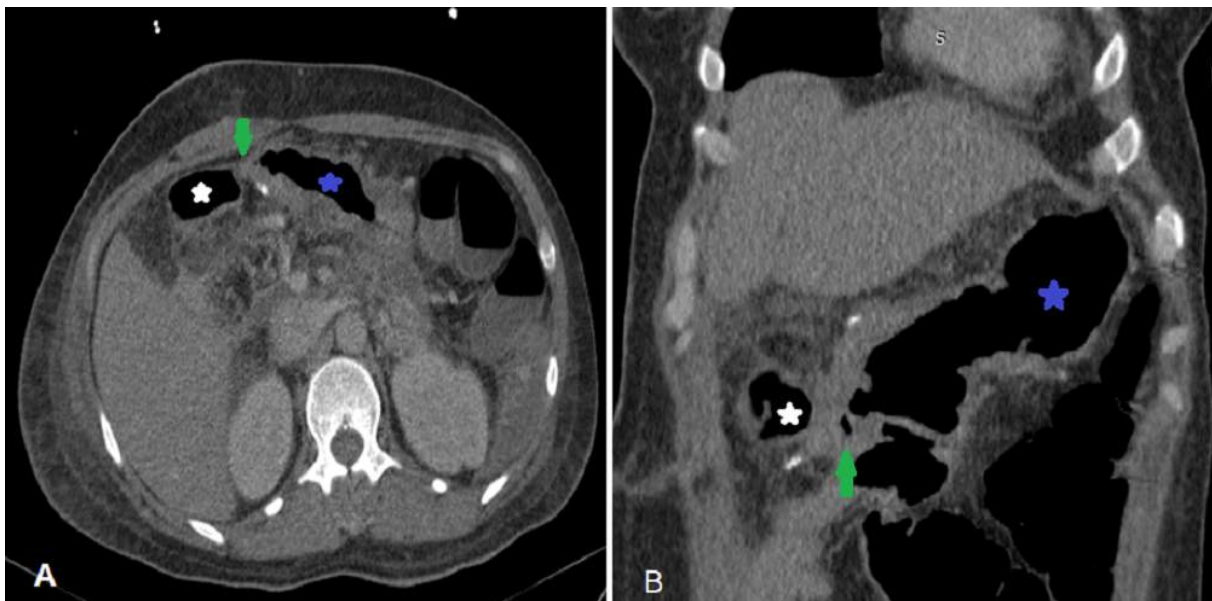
Non-injected abdominal and pelvic CT in axial (A) and coronal (B) sections showing the gastrojejunal anastomosis (green arrow) between the stomach (blue star) and the jejunum (white star). Note the presence of some spontaneously hyperdense clips
